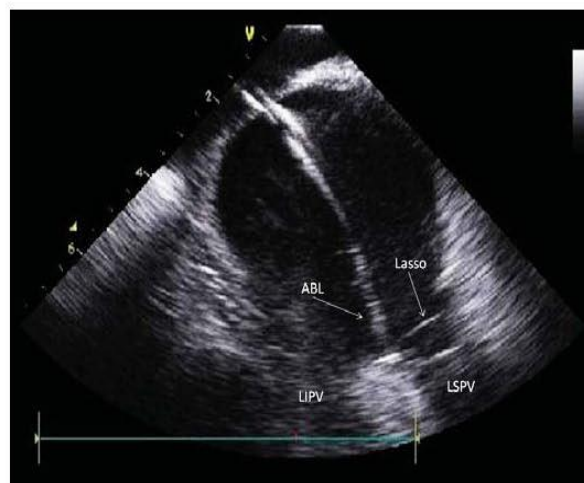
Intracardiac echocardiography image of left atrium. Ablation catheter (ABL) is sitting on the carina between left superior (LSPV) and left inferior (LIPV) pulmonary veins. Lasso: circular catheter in LSPV.
